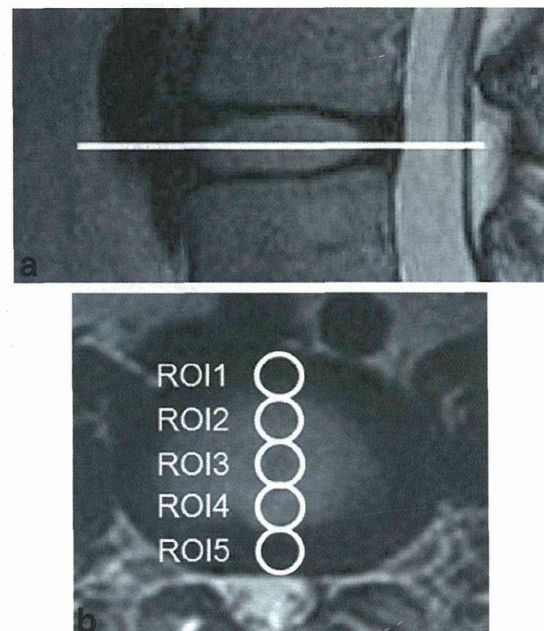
Positioning of the regions of interest (ROIs). The T2-weighted sagittal (a) and axial (b) images were used as anatomical references. Five equally sized circular ROIs (b) were manually drawn on the central slice of the axial planes (a, solid line) by a radiologist (M.K.), and were copied on the T2 maps and q-space images. Each ROI measured 20% of the midline disc diameter in the axial plane. The most anterior and most posterior ROIs (ROI 1 and ROI 5) were interpreted as anterior and posterior AF tissue, respectively. The ROIs in between were interpreted as nucleus tissue (ROI 2, anterior NP; ROI 3, middle NP; ROI 4, posterior NP).
